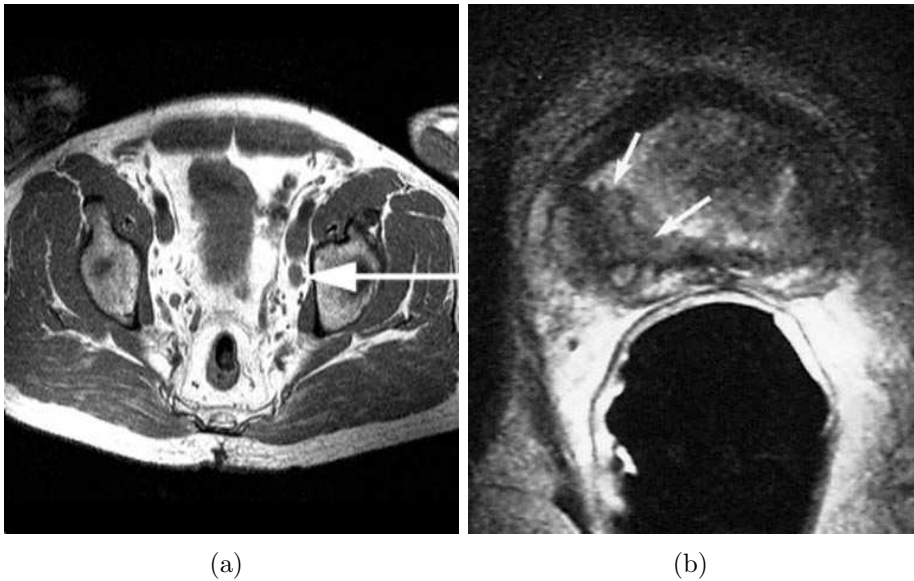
MRI of the prostate. (a) T1-weighted MRI scan of the pelvis shows an enlarged left obturator node (arrow) proven to be cancer by biopsy, (b) endorectal, axial, T2-weighted MRI scan in a patient with a right-sided prostate cancer. Low signal intensity is demonstrated in the right peripheral zone (arrow). Copyright ©1994-2012 by WebMD LLC.
